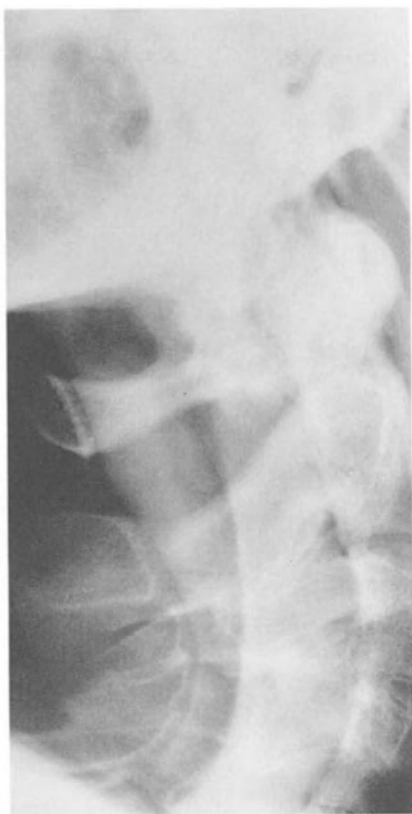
Lateral radiograph during water soluble myelography in a man who had been neurologically stable for 23 years. Note the large size of the cervical canal and the atrophic cord. There is still a hindbrain hernia visible, the tonsil tips are just above the arch of C1. There were no hindbrain features clinically. Since the cord has collapsed and partly calcified the probability is that the hindbrain has permanently disimpacted and does not need treatment
